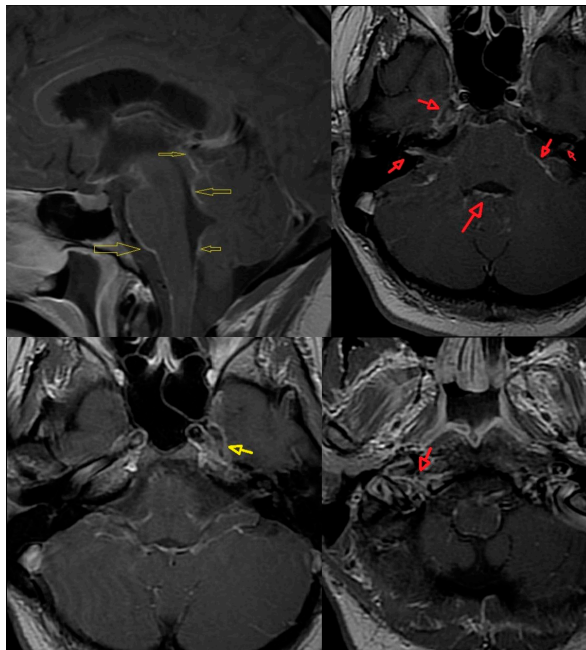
Brain MRI with gadolinium-based contrast agent shows a widespread leptomeningeal contrast enhancement on the surface of the brain supra- and infratentorial as well as intraventricular ependymal contrast enhancement and engagement of the cranial nerves. MRI with gadolinium-based contrast agent shows widespread contrast enhancement of the subarachnoid space in the spinal canal. T1WI on left, T1GDWI on the right.
